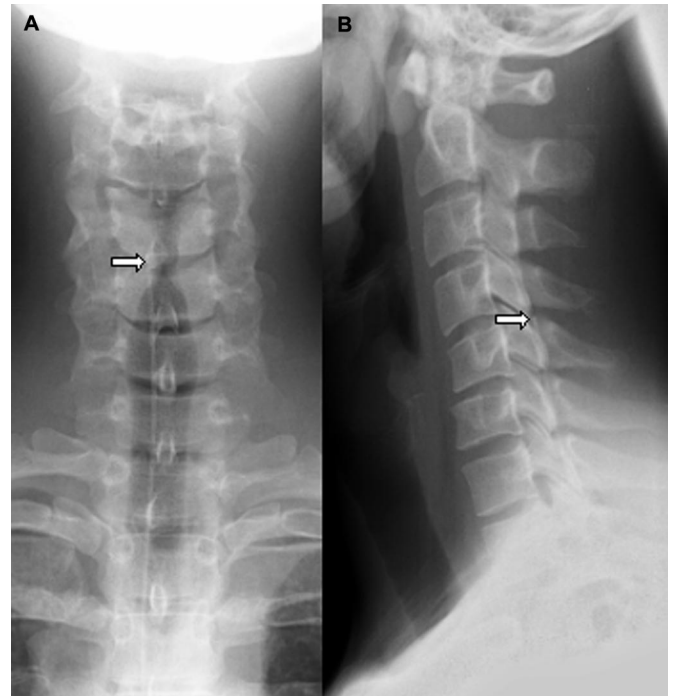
Plain x-rays demonstrating an intrathecal catheter tip (arrows) for baclofen administration in a mid-cervical position.
